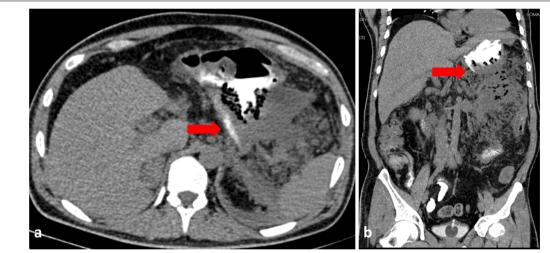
Computed tomography axial (a) and coronal (b) images showing extravasation of oral contrast through the stomach wall defect (red arrow)
